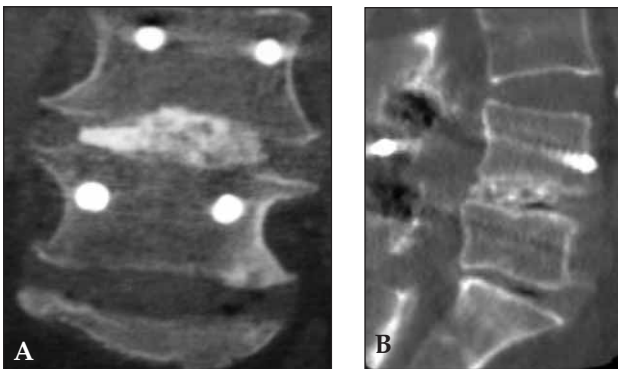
Images with coronal (A) and sagittal (B) reconstructions of the lumbar spine with fine-cut bone-window CT.
